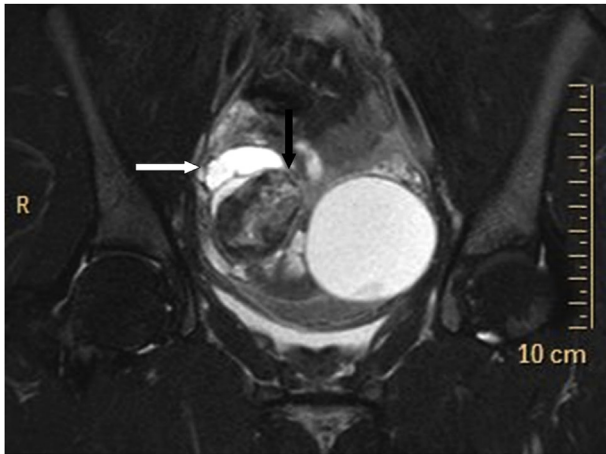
Axial T2-weighted image demonstrates a hypointense fluid level in the tubular structure, representing hemorrhage in the right fallopian tube (black arrow).
